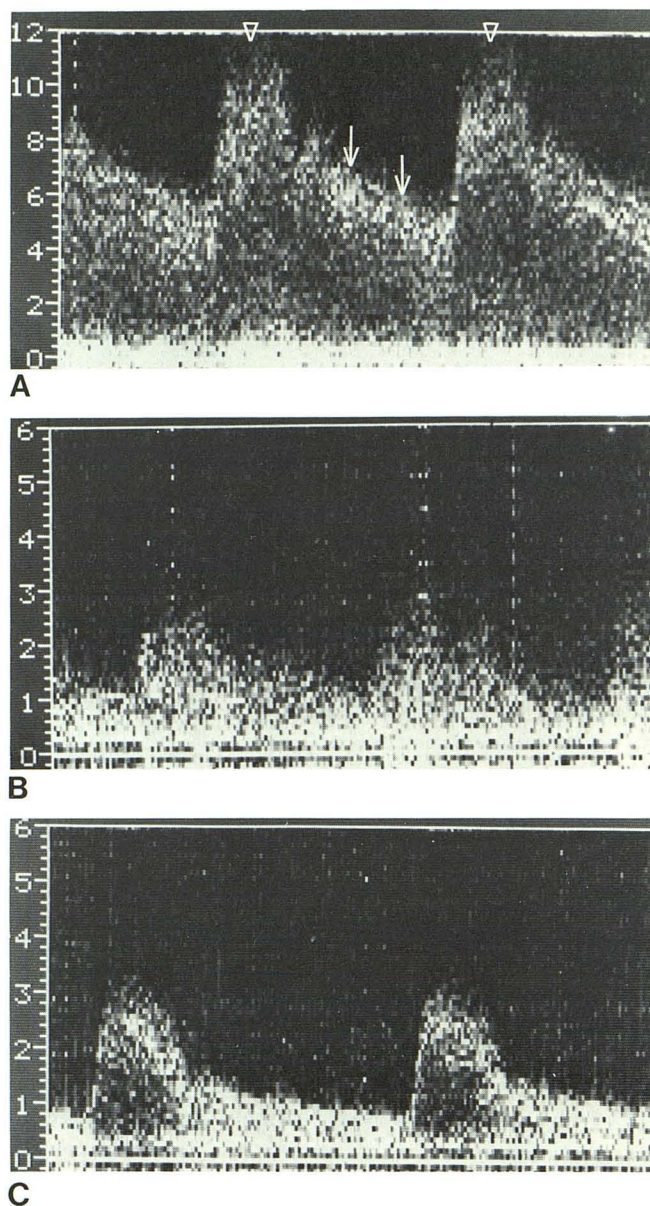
Sonographic representation of audible Doppler signals with hemodynamically significant stenosis. A, Stenotic zone. Markedly elevated peak systolic frequencies (arrowheads) and extension of high velocity flow into diastolic part of cardiac cycle (arrows). B, Poststenotic zone. Severe turbulent flow indicated by "filling in" of frequency spectrum. Localized reversal of flow signals (not shown) is also present. C, Normal internal carotid sonogram. (Note differences in scale among these and sonograms in following figures. Numbers at left represent kHz frequency.)
